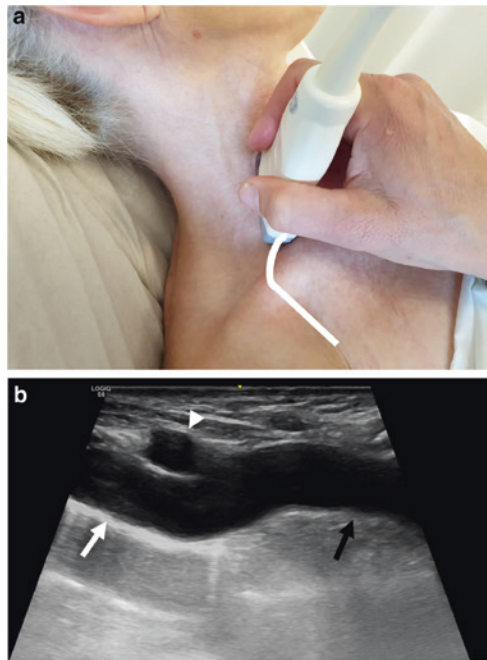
Examination of the right subclavian artery: a recommended transducer position, b ultrasonographic view of the brachiocephalic trunk (black arrow), carotid artery (arrowhead), subclavian artery (white arrow)
